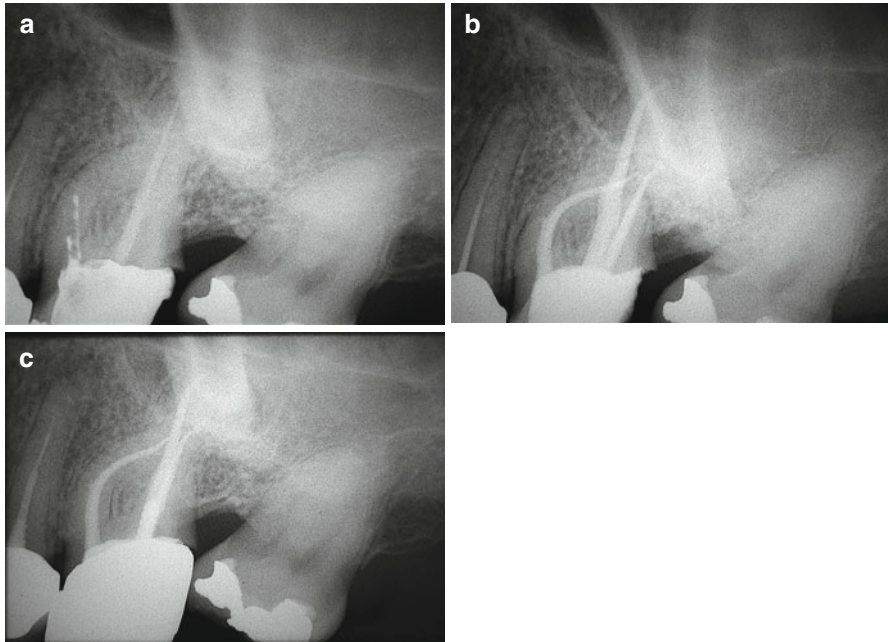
(a) Left maxillary first molar. Endodontic treatment is insufficient. There is a wide ledge corresponding to the MB1 canal at the boundary between the coronal and the middle thirds. (b) Postoperative radiograph showing retreatment. (c) Follow-up after 6 months
